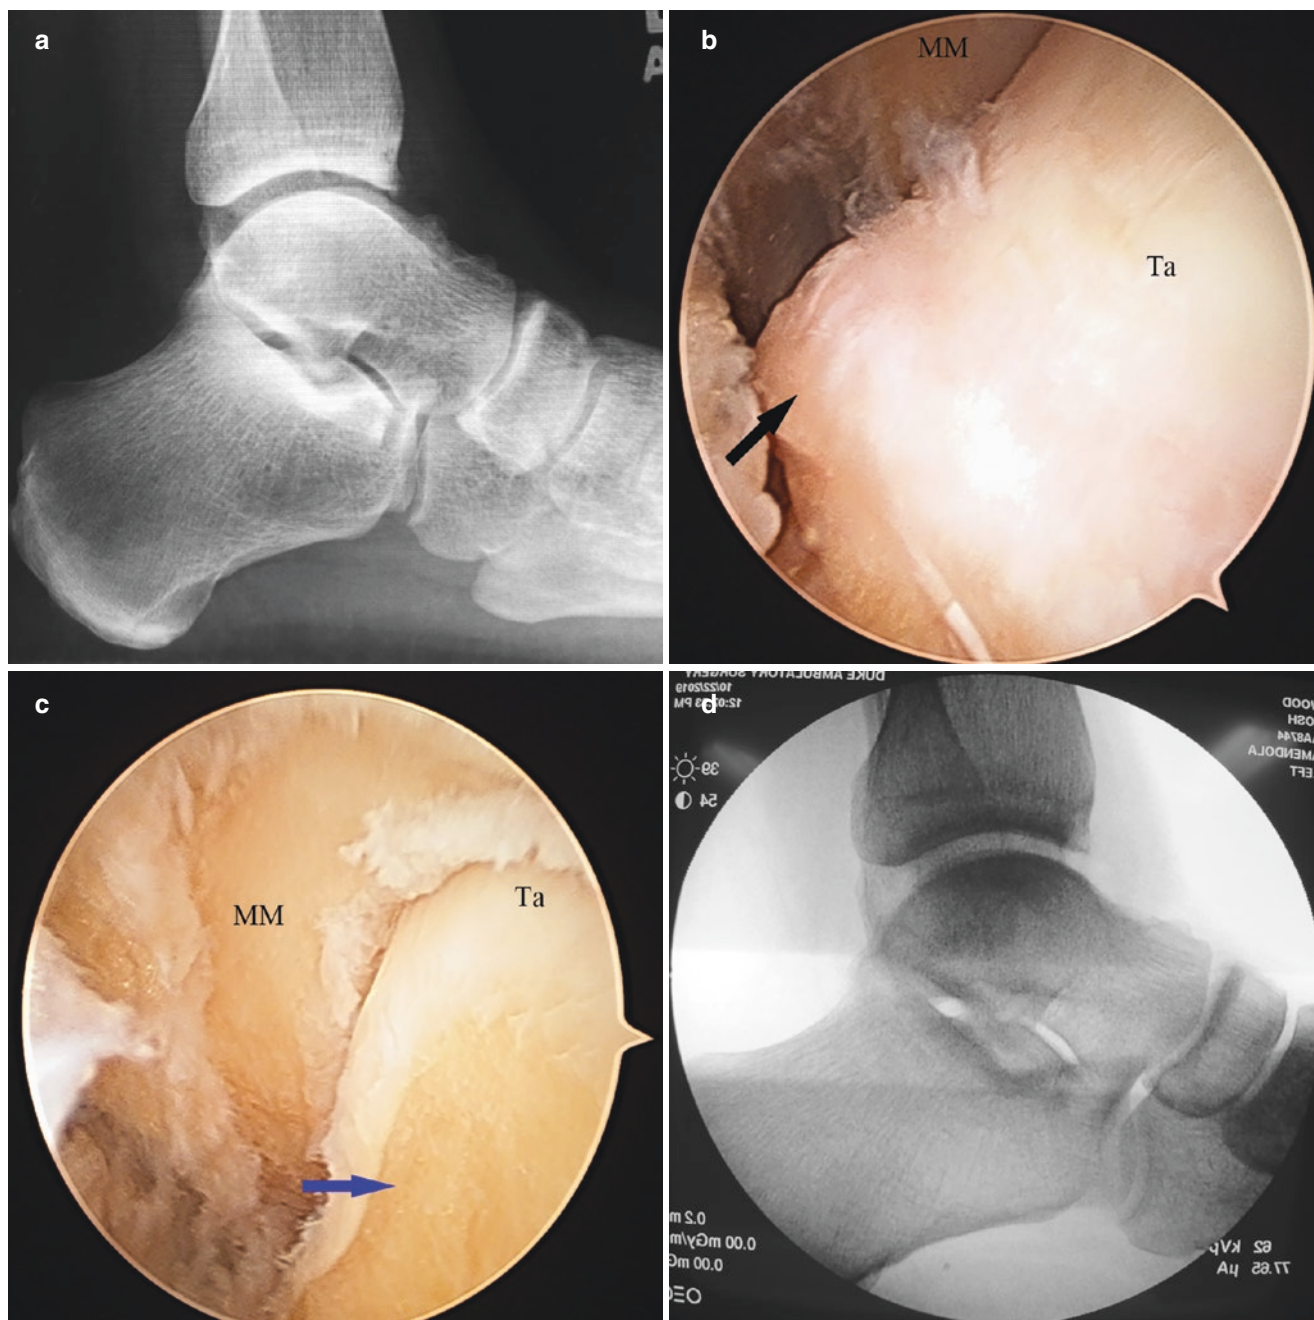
Cam impingement. (a) Preoperative X-ray with non-spherical nature of the talar dome. (b) Cam deformity. (c) Removal of the cam deformity. (d) Postoperative X-ray with normal spherical
